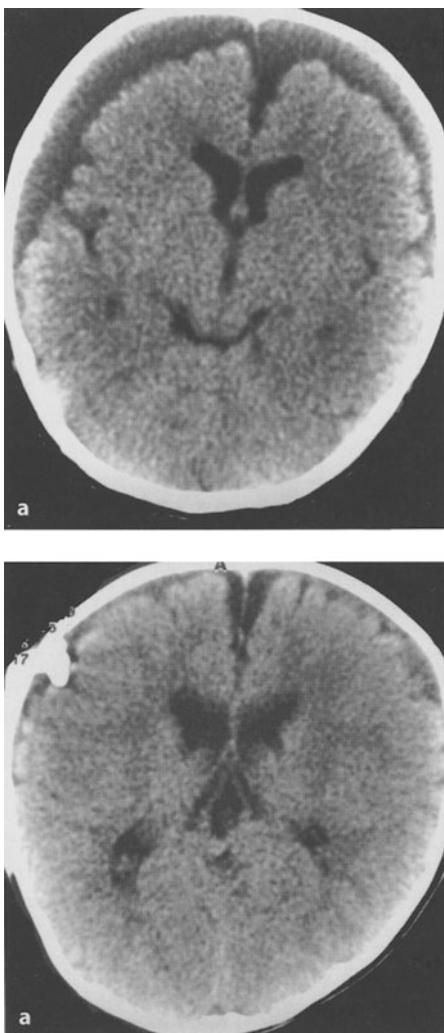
Surgical treatment of subdural collection with subdural-peritoneal shunt. a CT scan of a 5-month-old boy presenting with increasing head circumference. Bilateral subdural collections are present. The fluid of the collections has higher density than the underlying subarachnoid CSF, which creates a circumferential black halo around the brain. b CT scan obtained 4 months after insertion of a subdural-peritoneal shunt. The subdural collections had resolved completely. The subdural shunt was removed shortly afterwards
